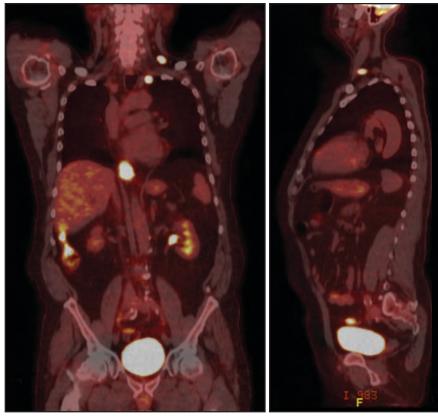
PET/CT images showing a hypermetabolic left level 1L node and left supraclavicular node.
